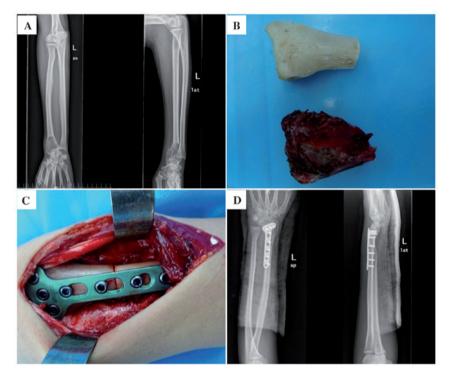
A 21-year-old female with Campanacci's grade III giant cell tumor of the distal radius on the left side and pathological fracture. The patient was treated with distal radial tumor segment resection, allogeneic bone segment graft and plate-screw internal fixation. (A) Preoperative anteroposterior (left) and lateral X-ray (right) examination revealed bone destruction and pathological fracture of the left distal radius. (B) The resected tumor segment of radius and trimmed allogeneic bone segment. (C) Postoperative photo following surgery. (D) Postoperative anteroposterior (left) and lateral (right) radiographs.
